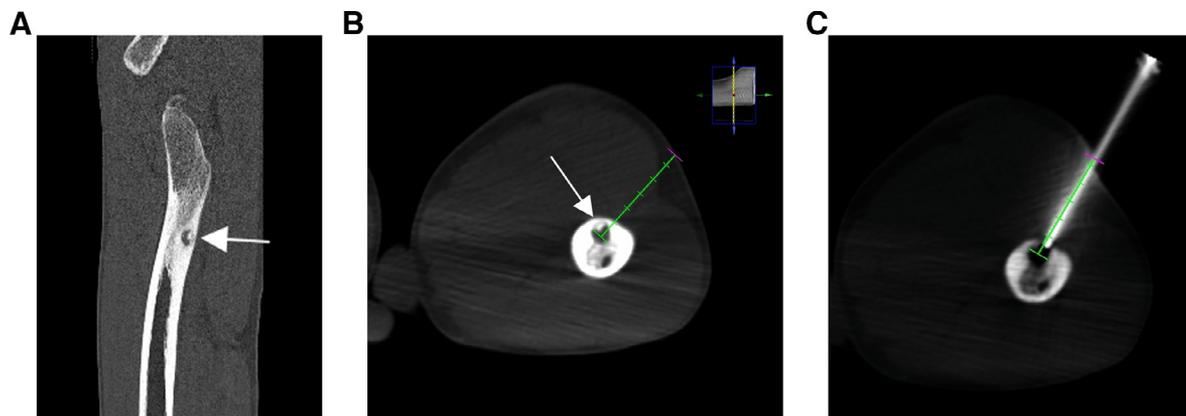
An 8-year-old boy with focal pain in his proximal thigh secondary to an osteoid osteoma of the proximal femur. Sagittal CT image (A) demonstrates classic imaging appearance including a focal lucent nidus (white arrow) with central sclerotic dot and surrounding reactive sclerosis. Intraprocedural axial CT image (B) prior to cryoablation demonstrates the nidus (white arrow). Intraprocedural axial CT image (C) after placement of introducer cannula through the cortex.
